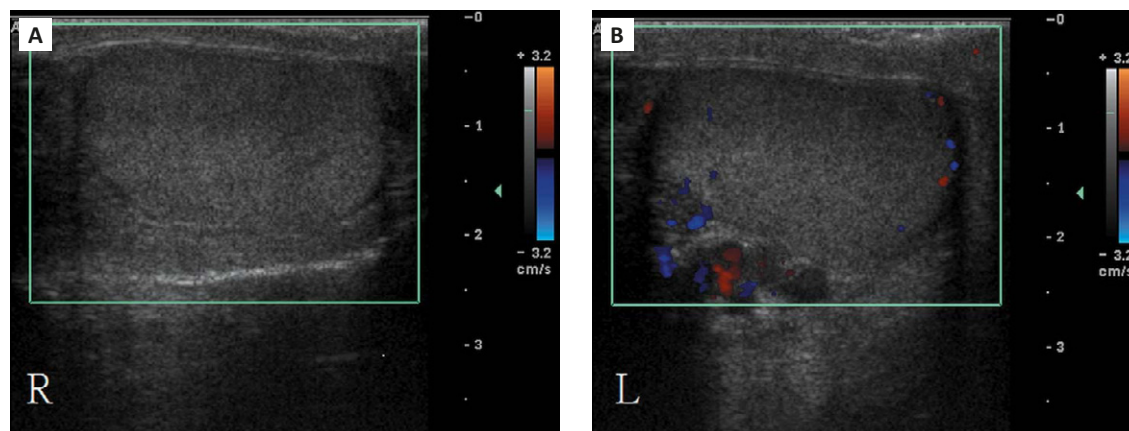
(A, B) Color duplex sonography shows normal sizes of both testes. (A) Vascular flow was not observed in the right (R) scrotum but (B) was observed in the left (L).
